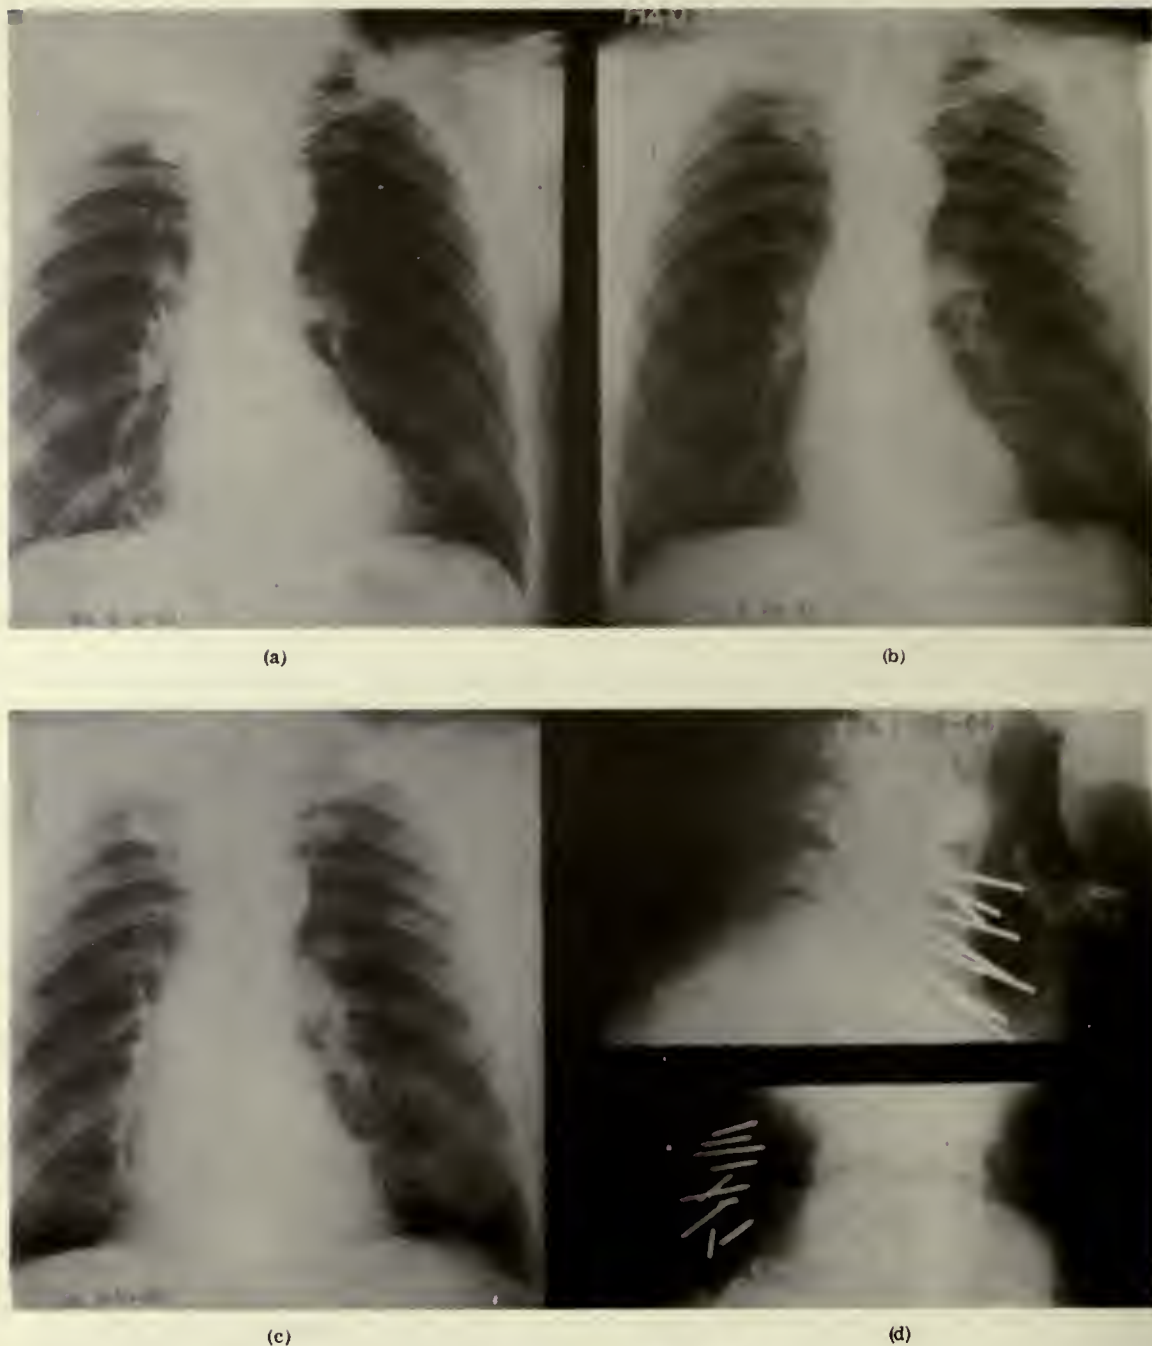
Patient with advanced Pancoast type carcinoma of right apex of lung and with supraclavicular lymph node, treated by two different technical methods. (a) Mass in the apex, extending into neck, with destruction of the first rib, at beginning of radium-beam treatment. (b) Film taken six weeks later, showing little change. (c) Roentgenogram taken six months later, demonstrating the regeneration of the first rib. (d) Anteroposterior and lateral views of the radium-needle implant in the neck mass.
